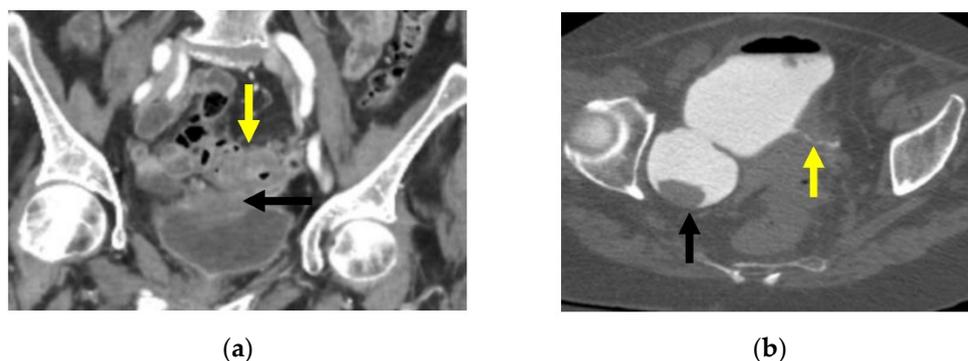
(a). Coronal CT image through the pelvis with IV contrast. There is segmental wall thickening of the sigmoid colon (yellow arrow) with multiple diverticulae. There is contiguous soft tissue density with the superior wall of the bladder (black arrow), suggestive of colovesicular fistula. (b). Axial image from CT cystogram. The bladder has been filled with contrast via Foley catheter. Tract is confirmed between the bladder and sigmoid colon (yellow arrow). There is also a large bladder diverticulum (black arrow).
